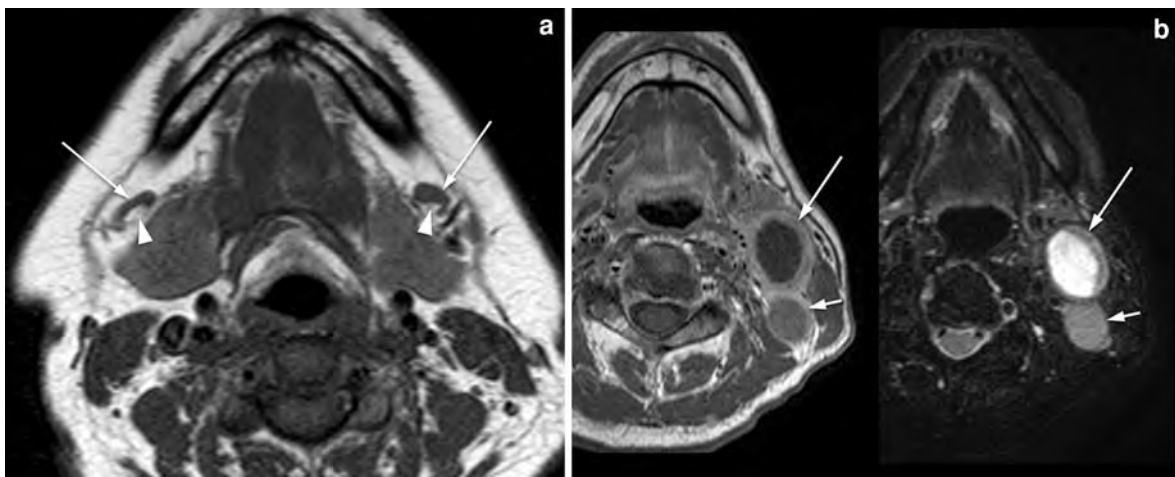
a Axial T1 W MRI showing normal bilateral submandibular lymph nodes (*arrows*) with identifiable hila (*arrowheads*). b Axial T1 W post contrast MRI (*left*) and T2 W fat saturated MRI (*right*) showing metastatic left level
